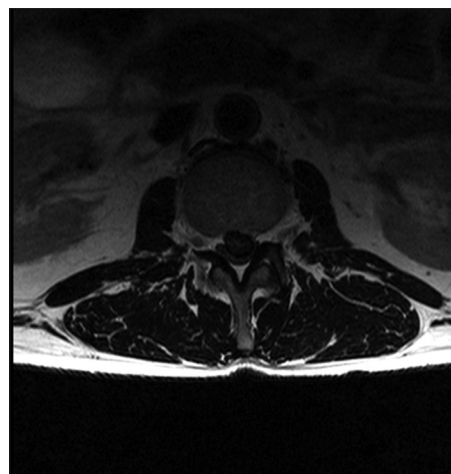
The immediate preoperative April 2015 axial magnetic resonance imaging study documented the same massive central-left sided L2–L3 lumbar disk herniation seen on the magnetic resonance imaging from December of 2014. It still resulted in severe central-left sided thecal sac and left L2 and L3 foraminal/lateral root compression respectively
